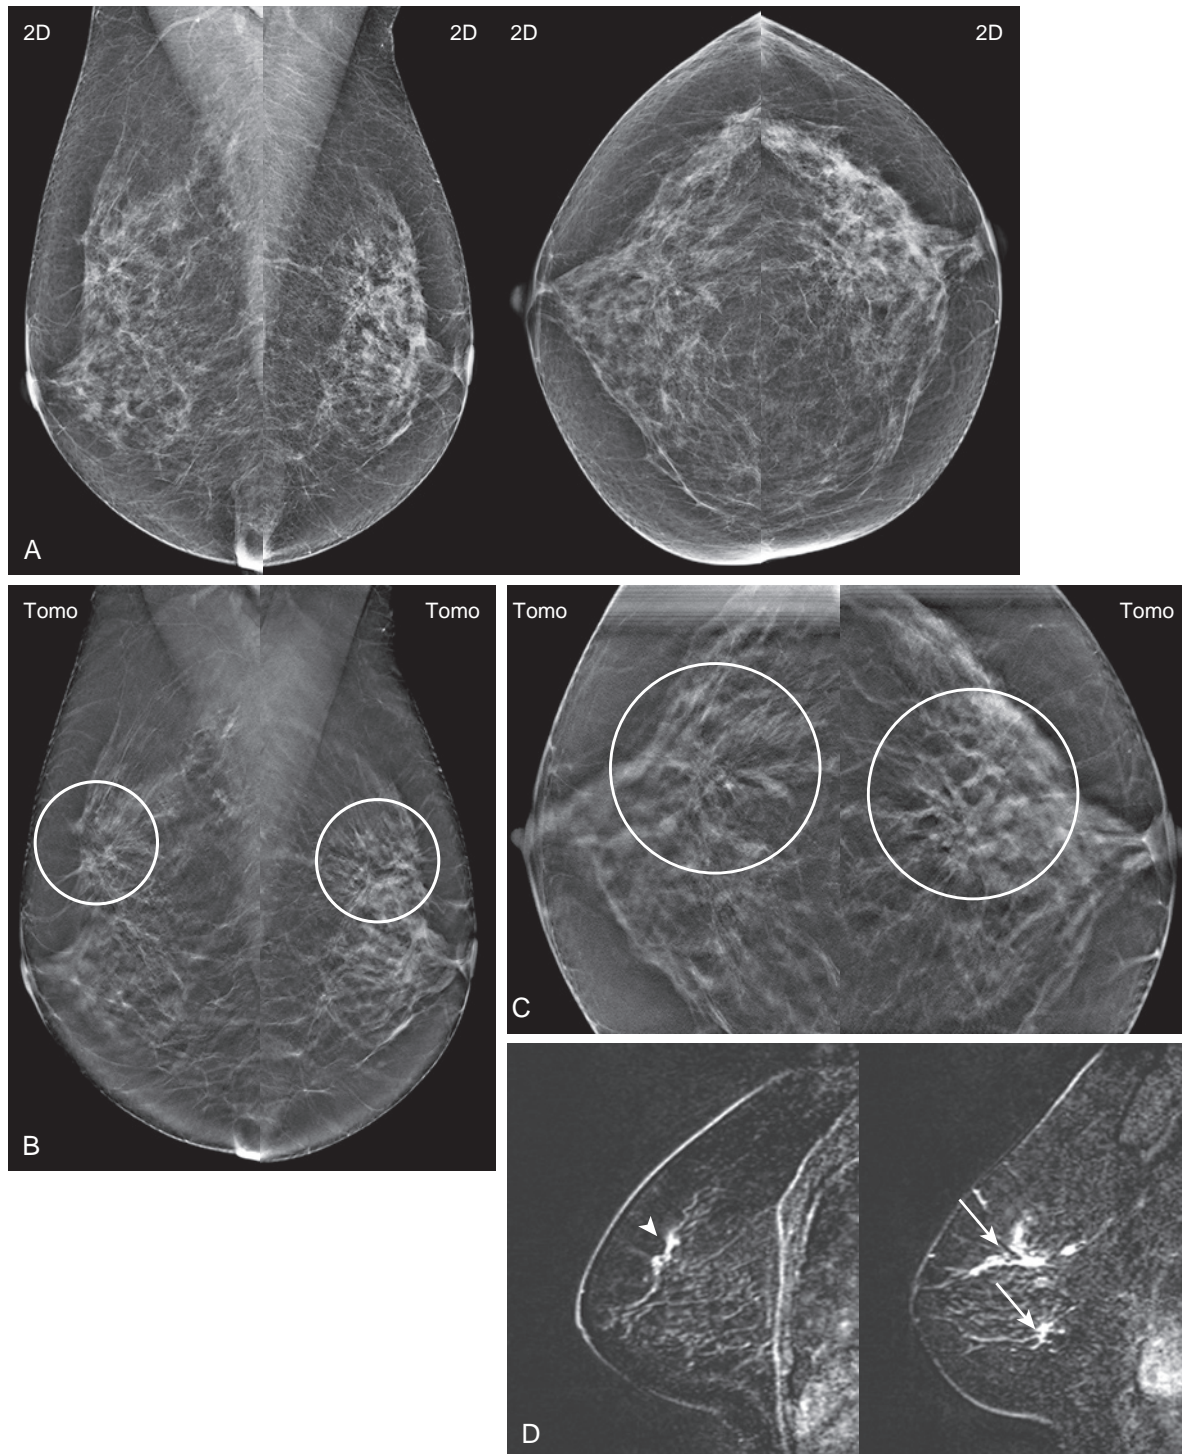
Bilateral multicentric ductal carcinoma in situ not seen on two-dimensional mammography or ultrasound (A) Screening mammogram in a 60-year-old woman demonstrates scattered fibroglandular tissue with no suspicious findings and no change in comparison to her previous mammograms (not shown). (B) Tomosynthesis mediolateral oblique views demonstrate bilateral architectural distortions (*circles*). (C) Spot compression craniocaudal and tomosynthesis views confirm the architectural distortions located at approximately the 12-o'clock position bilaterally (*circles*). (D) No corresponding mass was seen on targeted ultrasound, and magnetic resonance imaging (MRI) was performed. T1-weighted, fat-suppressed, contrast-enhanced sagittal views demonstrate an area of nonmass enhancement in the right breast (*arrowhead*) and two abnormal areas of nonmass enhancement in the left breast (*arrows*). MRI-guided core needle biopsy yielded ductal carcinoma in situ (DCIS), grade 2, ER/PR– at all three sites. The patient underwent a bilateral mastectomy, which revealed a 5.7-cm area of DCIS in the left breast and a 2.5-cm area of DCIS in the right breast.
